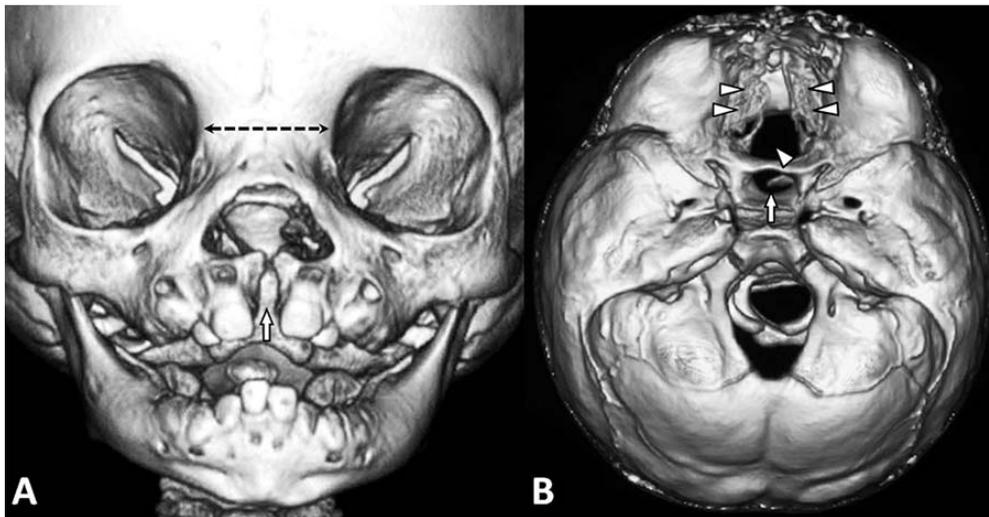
A) a 3D-CT reconstruction of the skull reveals midline bifid maxilla (arrow), hypertelorism (dotted bidirectional arrows) and elongated optic canal; B) a 3D-CT reconstruction of the skull base demonstrates basal skull defects at the sella turcica (arrow) and anterior cranial fossa (arrowhead) with lateral displacement of the cribriform plates (double arrowheads).
